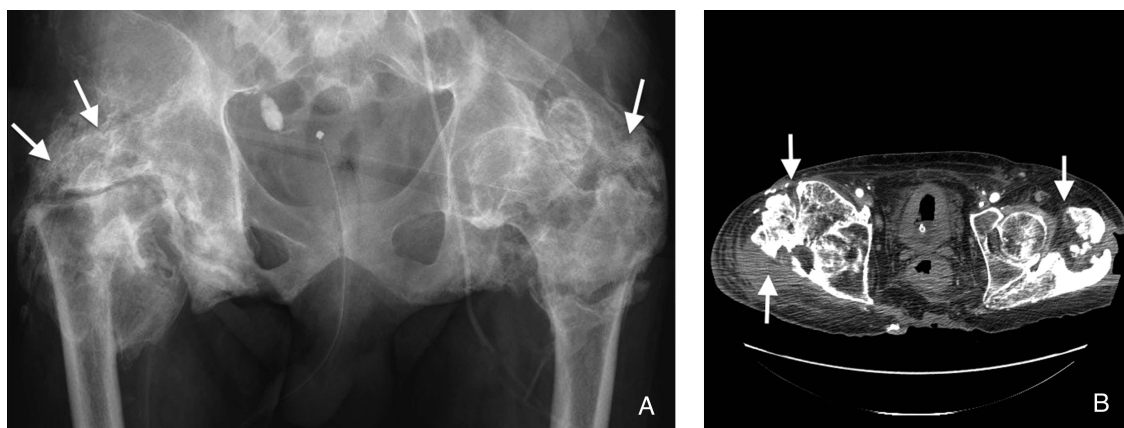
Plain radiograph of the pelvis (A) and computed tomography scan (B) ruled out neoplasm or chronic osteomyelitis in this patient.
